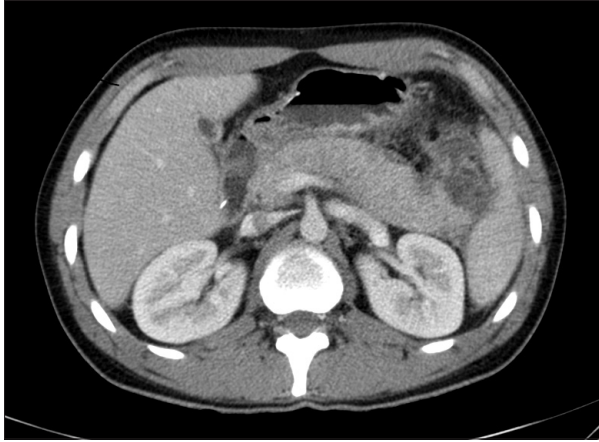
Computed tomography scan of enlarged sausage-like pancreas prior steroid treatment.
